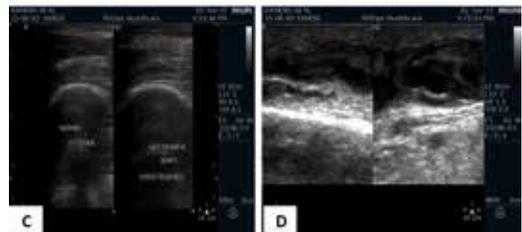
Fig C&D SHOWING ULTRASOUND IMAGES SHOWING INCREASED MUSCLE BULK, FEMUR SHAFT HYPERTROPHY AND DILATED SUBCUTANEOUS VEINS ON LEFT SIDE.
